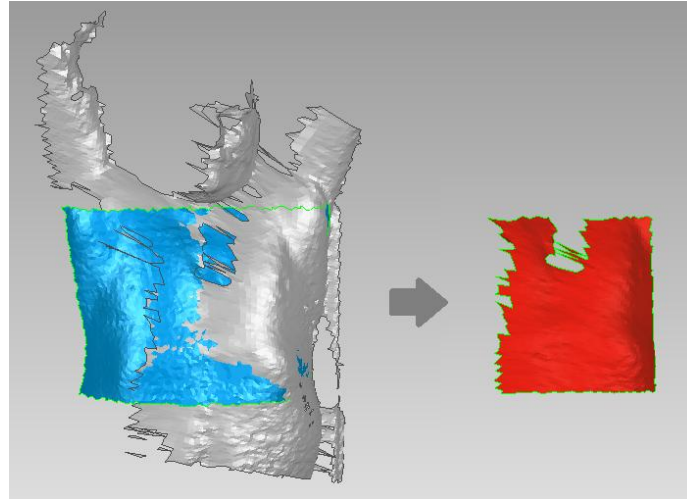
Thoraco-abdominal region of interest (red mesh) selected as the intersection between the patient's surface acquired with the optical system during treatment (grey mesh) and the surface extracted from the CT planning image (blue mesh).
